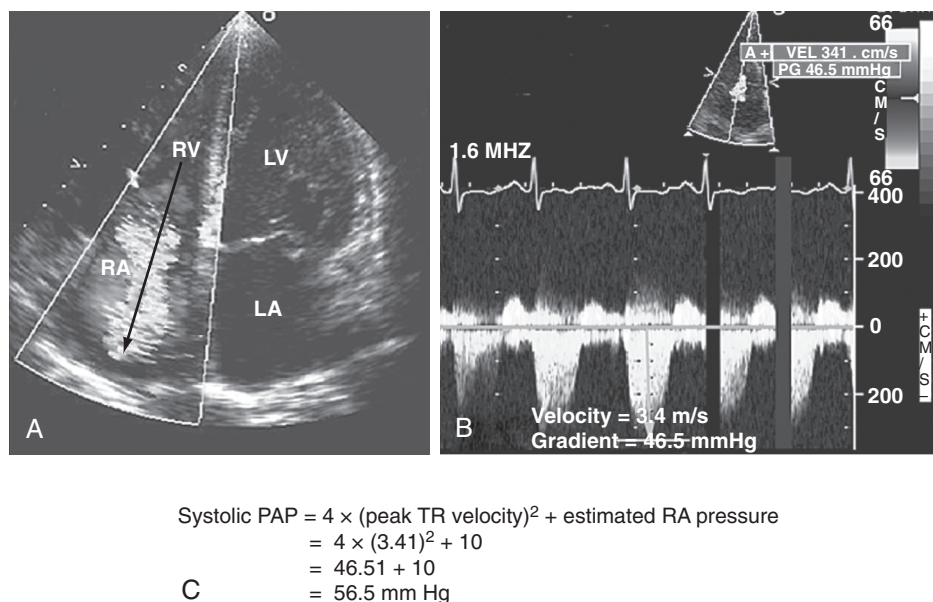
■ Calculation of systolic pulmonary artery pressure (PAP). A, Color Doppler transthoracic apical four-chamber view showing a significant tricuspid regurgitation (TR) jet from right ventricle (RV) to right atrium (RA). The peak tricuspid regurgitation velocity is measured by placing the continuous wave Doppler in the center of the tricuspid regurgitation jet (arrow). B, Spectral continuous wave Doppler profile of the tricuspid regurgitation jet. Peak tricuspid regurgitation velocity (3.41 m/s) and peak systolic pulmonary artery pressure gradient (46.5 mm Hg) can be obtained with this modality. C, Peak systolic pulmonary artery pressure also can be determined from the peak tricuspid regurgitation Doppler velocity using the modified Bernoulli equation: $\Delta P = 4 \times (\text{peak tricuspid regurgitation velocity})^2$. To this peak systolic pressure gradient between right ventricle and right atrium is added the estimated right atrial pressure (determined to be 10 in this example) to obtain the peak right ventricular systolic pressure. In the absence of pulmonic stenosis or right ventricular outflow obstruction, peak right ventricular systolic pressure is equal to systolic pulmonary artery pressure. LA, left atrium; LV, left ventricle.
